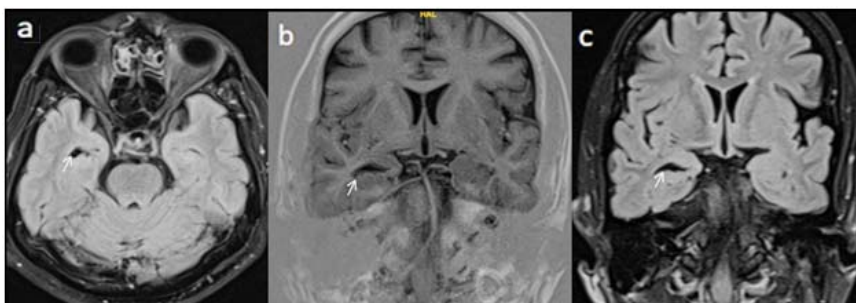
(a) Axial FLAIR, (b) T1 oblique Coronal, (c) FLAIR oblique coronal showing loss of striations on the right side with loss of volume in right hippocampus
